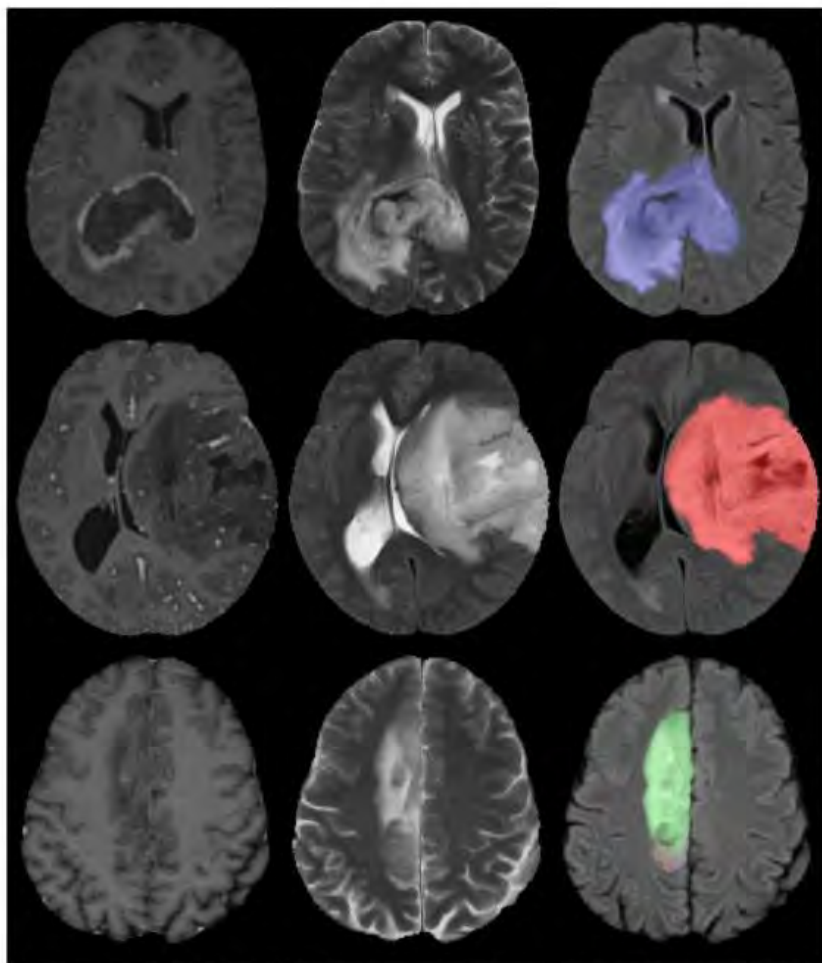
Images and IDH/1p19q AI output classification images from the local testing dataset. From left to right: T1 post-contrast, T2 and FLAIR with classification overlay. From top to bottom: IDH wild-type GBM (blue), IDH mutant - 1p19q intact astrocytoma (red), IDH mutant - 1-19q codeleted oligodendroglioma (green).
